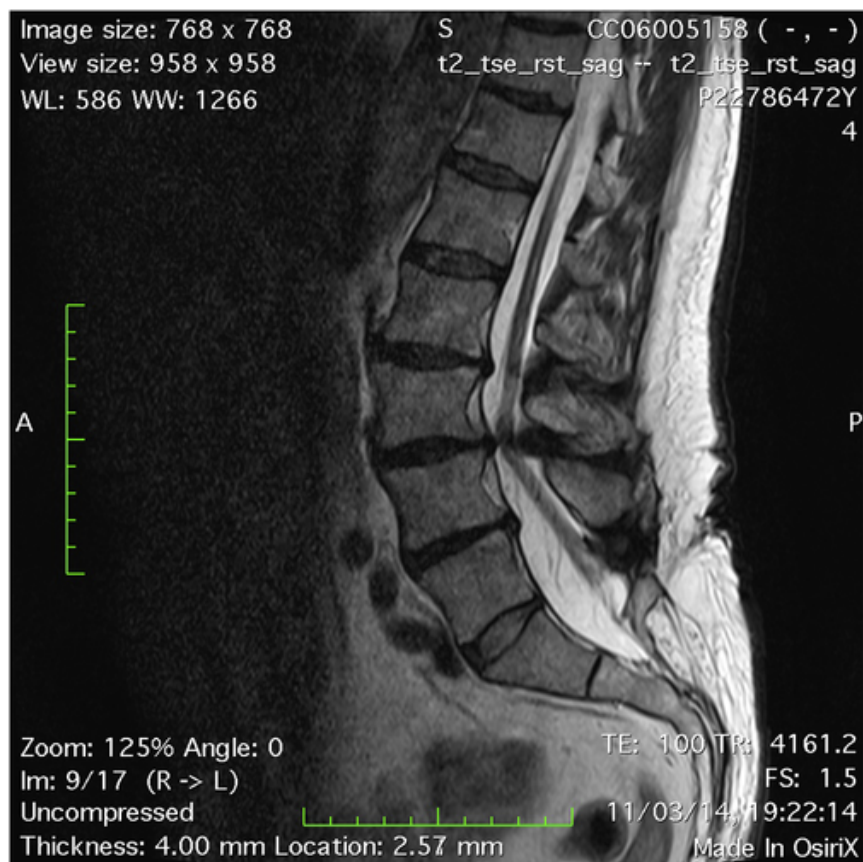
Preoperative lumbar MRI T2W-images: sagittal view. Signs of previous surgical intervention at sacral level and low lying cord associated with severe canal stenosis at L3-L4, caused by ligamentum flavum hypertrophy, L3-L4 disc prolapse and osteophytes.
